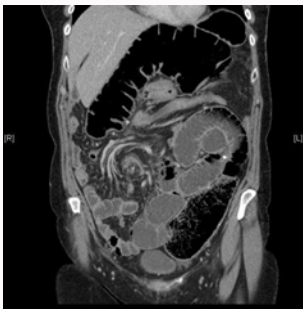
CT image showing the "whirl sign" appearance.
